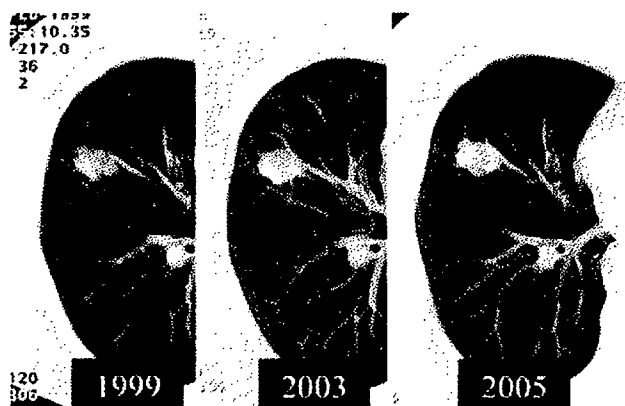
Chest CT scan of Case 1. Tumor size was 25 × 15 mm on Feb. 26, 1999 (2a), 25 × 20 mm on Sep. 5, 2003 (2b) and 25 × 23 on Mar. 9, 2005 (2c). The size of the nodule became enlarged from 25 × 15 mm to 25 × 23 mm in six years.
